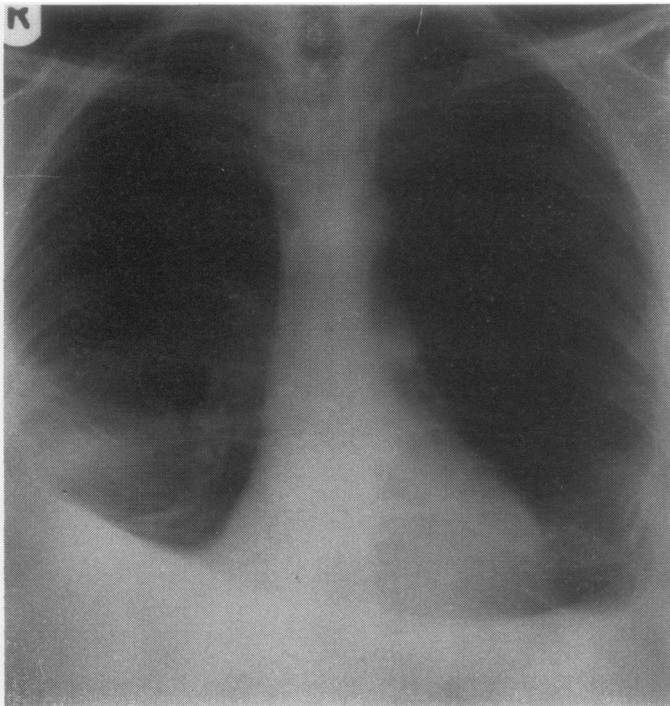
Case 1. Chest radiograph showing bilateral pleural fibrosis.
